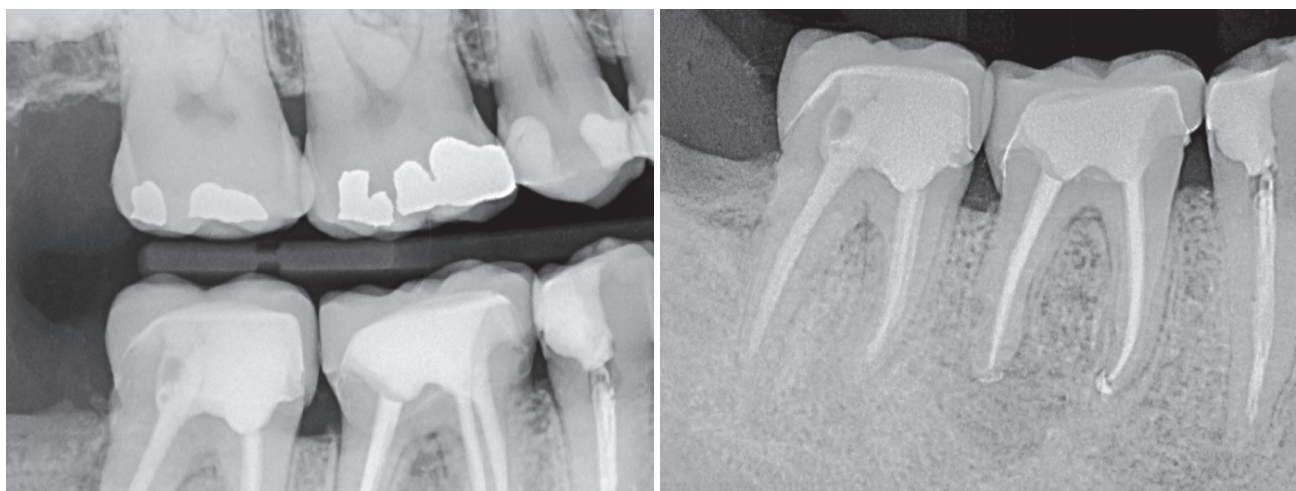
Final radiographs showing the good cervical adjustment of the crowns.
